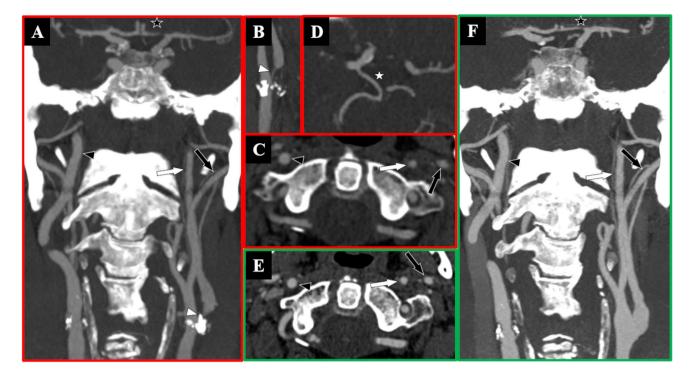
A case with right-sided near-occlusion without full collapse. A–E (red frame) are before carotid stenting and F–H (green frame) are after carotid stenting, with a clear increase in ipsilateral distal ICA size. A–C Preoperative CTA. Beyond severe stenosis, the right distal ICA is smaller than the left ICA and similar to the ECA. However, distal ICA is otherwise a well-seen lumen. D–E Pre-stenting series. D shows spontaneous cross-filling collaterals from the contralateral injection, via anterior communicating artery (black star). E
